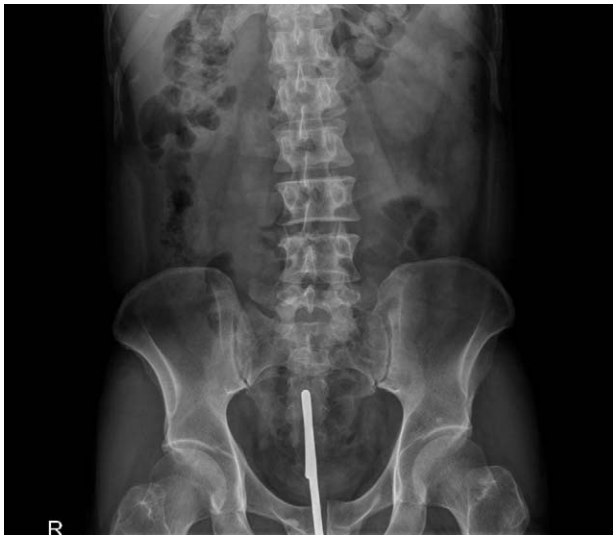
Abdominopelvic CT, sexual toy glass in rectum.
